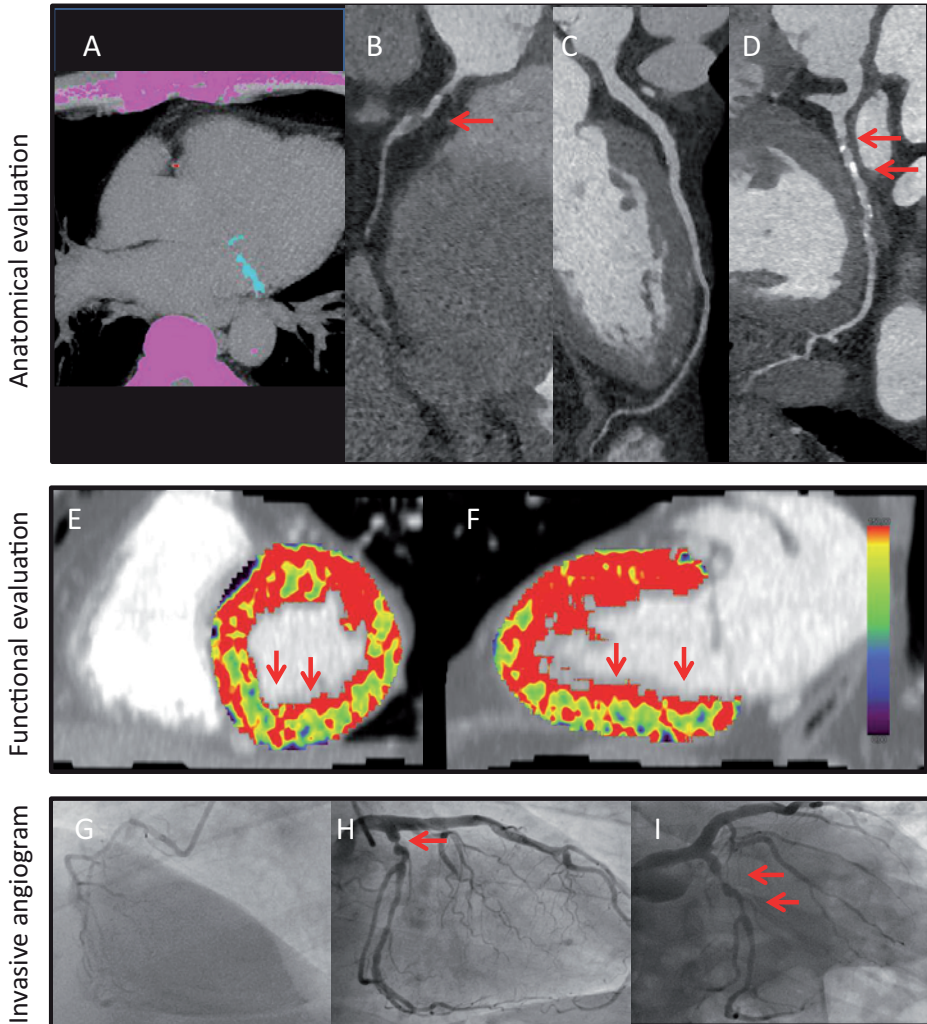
Case example of the comprehensive cardiac CT protocol. 52-years-old man with atypical angina, randomized to cardiac CT. Agatston score: 338.6 (A). CT-angiography: diffuse narrowing (50-70%) in the proximal, small RCA (arrow)(B), normal LAD (C), two 50-70% stenoses in the Cx(D). CT-MPI: low myocardial blood flow (0.55-0.73ml/min/g) in inferior wall (green-blue, arrows)(E,F). Invasive angiography: confirmed Cx lesions (H-I) were percutaneously treated(H-I), RCA regarded too small for revascularization(G).
